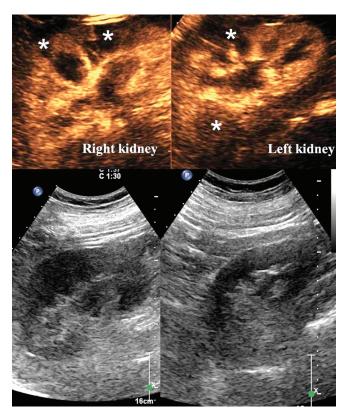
Right and left kidneys: Bottom panel before contrast ultrasound injection, Upper panel after contrast-enhanced ultrasound injection, imaging shows multiple areas of emboli lesions (white stars)
